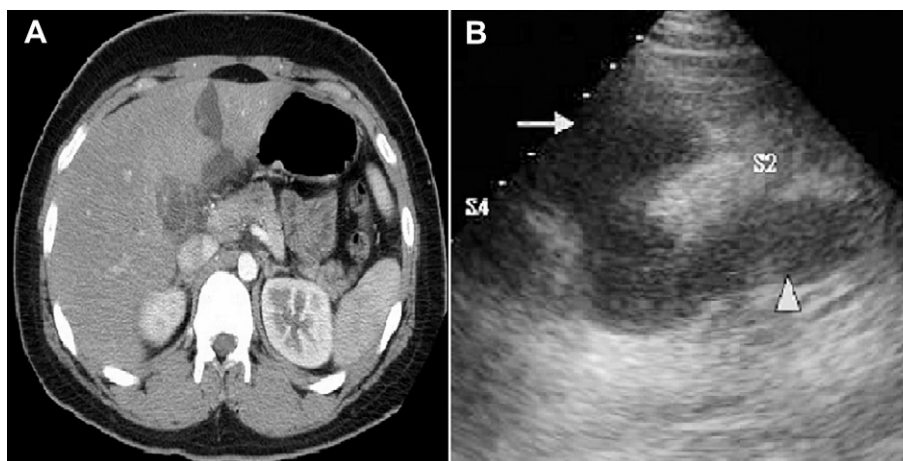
(A) CT: The lesion along with the falciform ligament communicates with the perihepatic area. (B) Perihepatic abscess, case 9: Perihepatic fluid collection (arrowhead); the lesion is in line with the falciform ligament (arrow).
